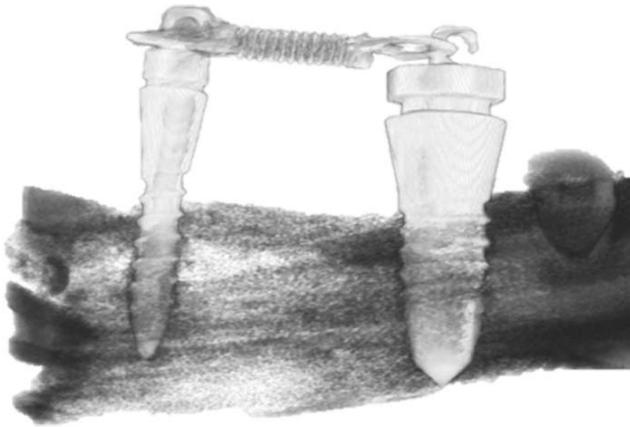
Micro-computed tomography image of devices loaded with 2N forces with calibrated coil springs. These images assisted in sectioning the screws along the long axis in the desired orientation.
